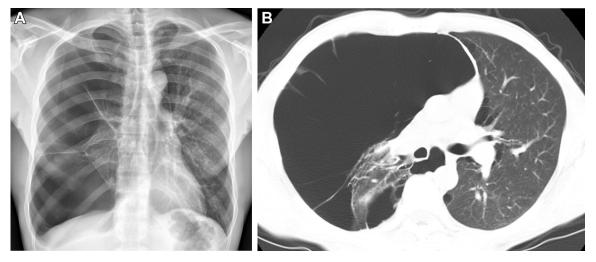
A, Posterior-anterior chest radiograph in a 44-y-old man with 10 pack-years smoking history and idiopathic giant bullous emphysema (vanishing lung syndrome) showing a hyperexpanded right hemithorax with severe bullous changes, and associated medial displacement and compression of the residual lung parenchyma in the right lower lobe. B, Axial CT image on lung windows in the same patient showing hyperexpansion and bullous replacement of the right lung with relative sparing of the compressed right lower lobe.
